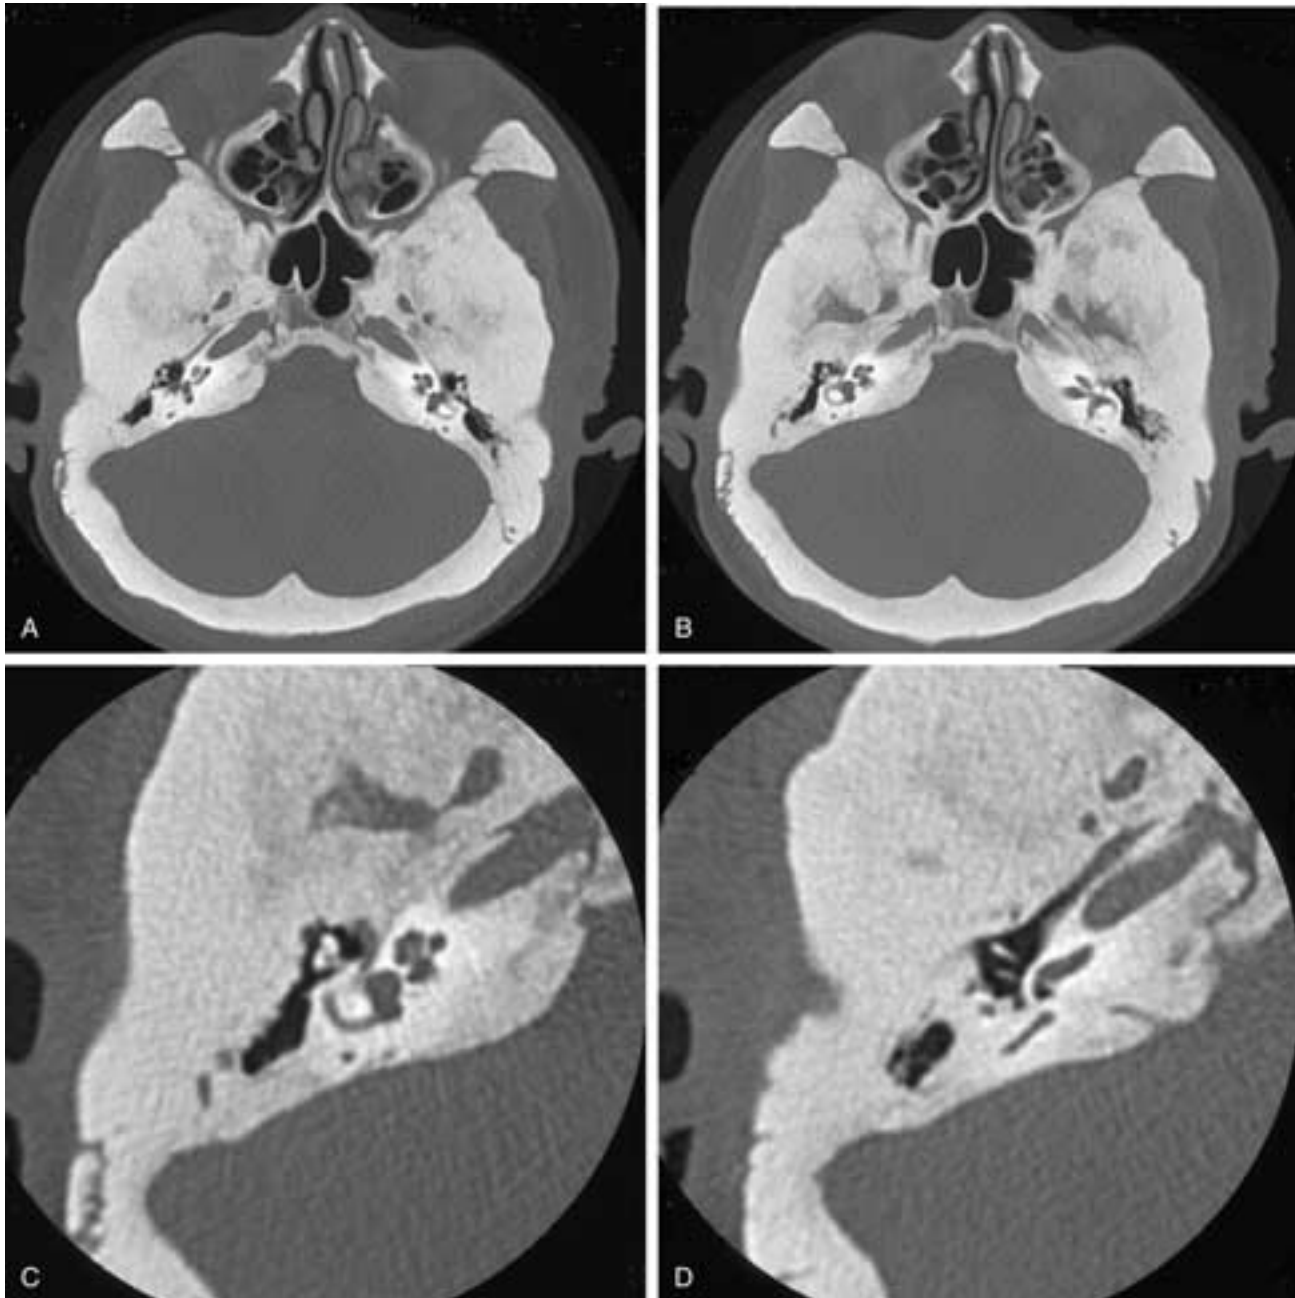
Progressive diaphyseal dysplasia (Engelmann's disease). A and B, Axial CT images demonstrate marked thickening and sclerosis of the entire bony structure of the skull base, including the temporal bones. C and D, Axial images of the right ear demonstrate narrowed middle ear cavity, while the lumen of the labyrinth is preserved. (Courtesy of Dr. Kenichi Nagasawa, Asahikawa, Japan.)
